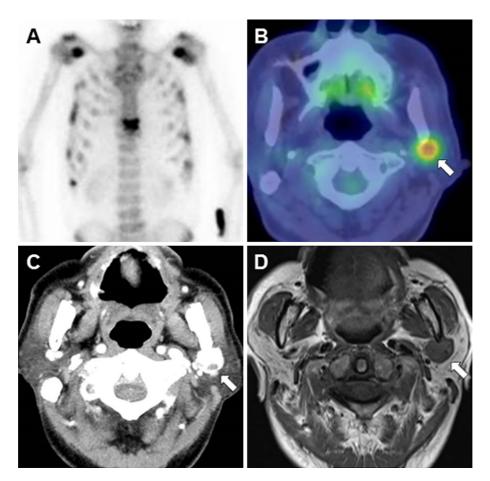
A) Bone scintigraphy with technecium-99m methylene diphosphonate revealed multiple high-uptake lesions in several sites, including the ribs and shoulders. B) PET/CT indicated the uptake of [18F] fluorodeoxyglucose in the left parotid gland with a maximum standardized uptake value (SUV) of 5.1. Contrast enhanced CT (C) and T1-weighted MRI (D) revealed the presence of the tumor in the left parotid gland.
